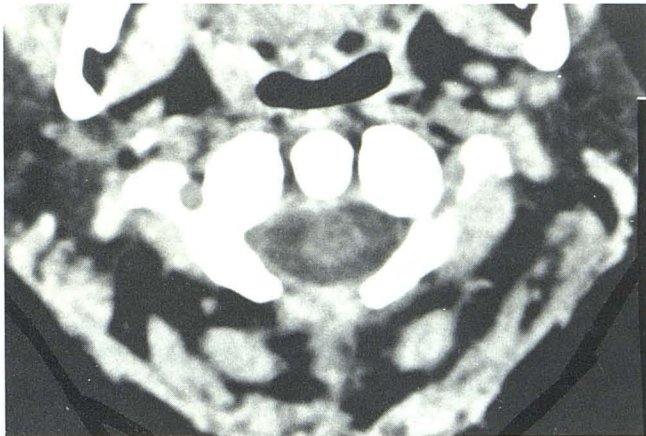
Postoperative noncontrast CT scan. Clot has been evacuated and cervical cord is now in normal position.
